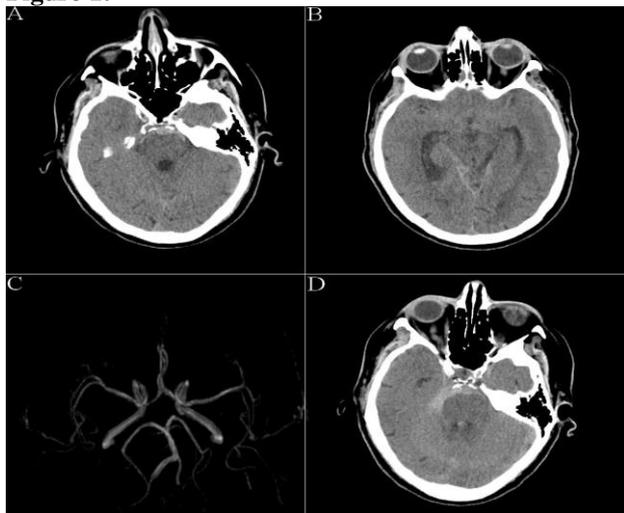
(A,B) Axial, non-contrast enhanced, head, computerized tomography (CT) scan demonstrating perimesencephalic subarachnoid haemorrhage, (C) Brain, Magnetic Resonance Angiography did not reveal any vascular abnormalities, (D) Axial, non-contrast enhanced, head, CT scan significant for rebleeding.
